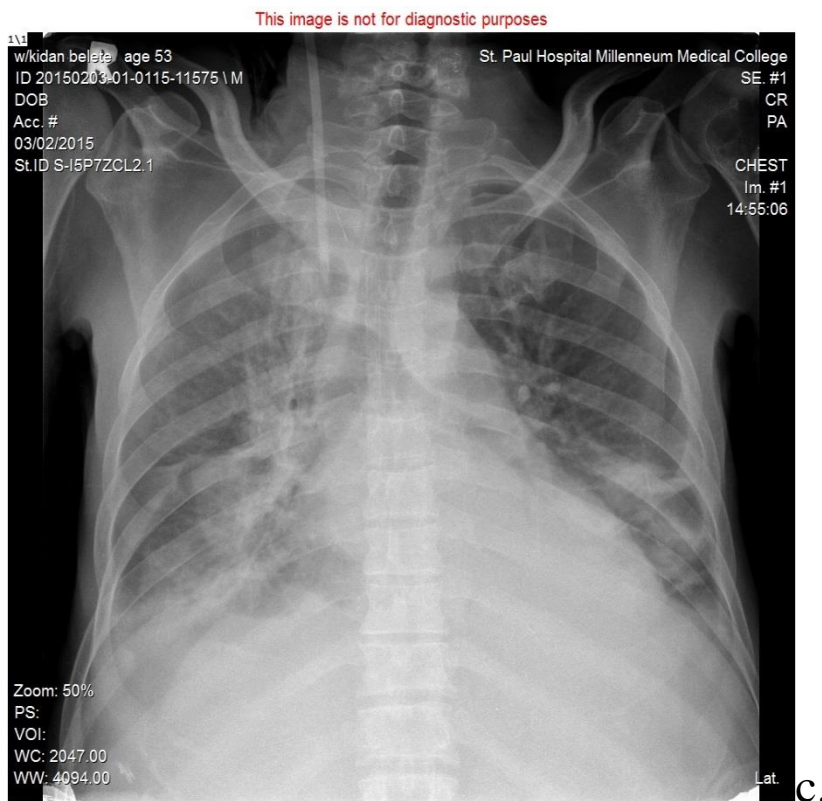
sample CXRs, demonstrating a.severe MS (echocardiography confirmed), b. lymphangitis carcinomatosa and c. pneumothorax with pachy consolidations
